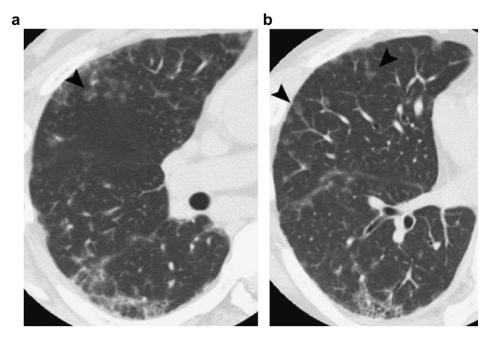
HRCT findings of centrilobular nodular opacity in an anti-synthetase positive case. Small-size nodules with ground glass densities are distributed in centrilobules (arrowhead) in the right middle lung (4-a) and in the right lower lung (4-b), respectively.
